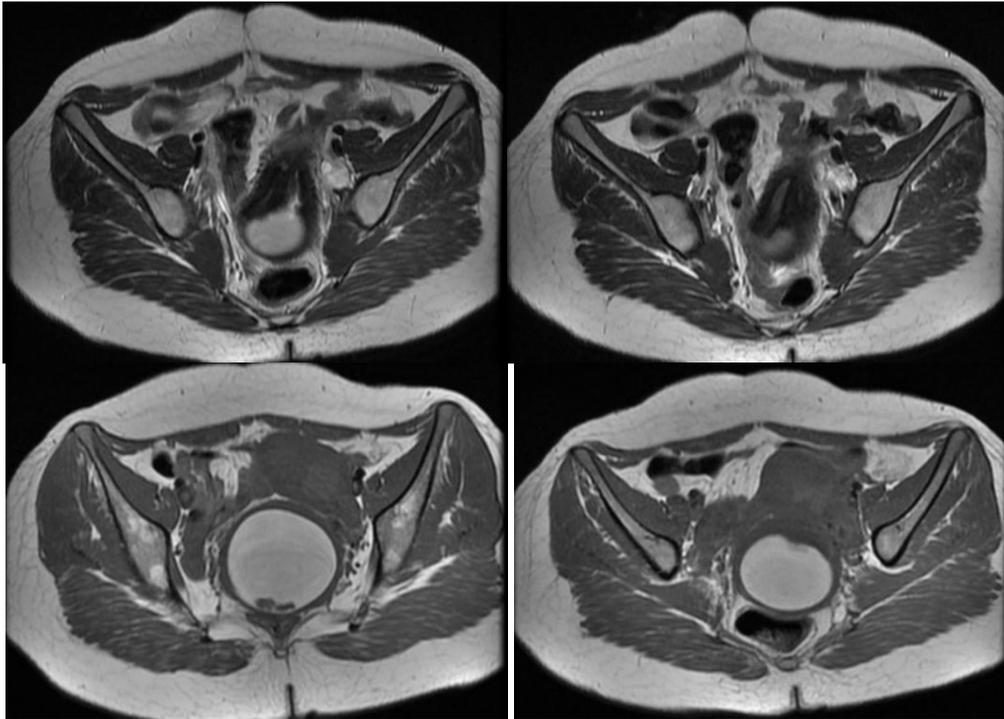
Axial MRI images (cranial to caudal) showing two separate uteri (top right image) each with separate cervix (top left image) and vagina (middle right image) with e/o small communication between the two at the level of cervix (top left image). The left hemivagina was overdistended, showing high signal intensity contents on T1W (bottom row images) as well as T2W (top and middle row images) s/o haemorrhagic contents along with dependent blood clots. The haemorrhagic contents (mildly hyperintense on T1) were also seen in both the uterine cavities (left > right). The right vagina was stretched and pushed laterally by the over distended left vagina.
